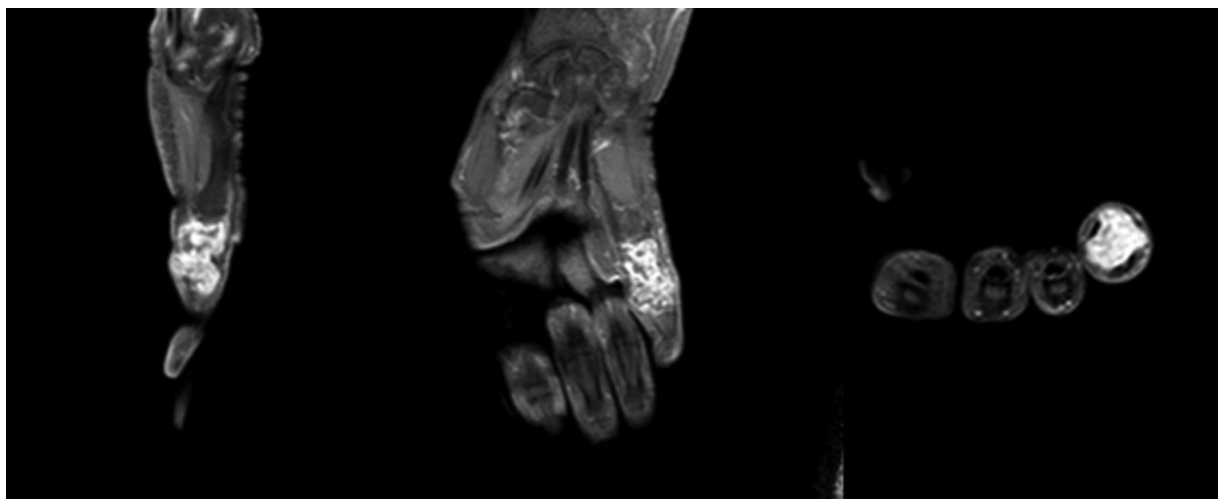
Tumor lesion of the proximal phalanx of the little finger. Its characteristics and the previous radiographic study indicate a chondroid tumor with malignancy signs resulting from its extraosseous extension (chondrosarcoma) with no involvement of adjacent joints.
